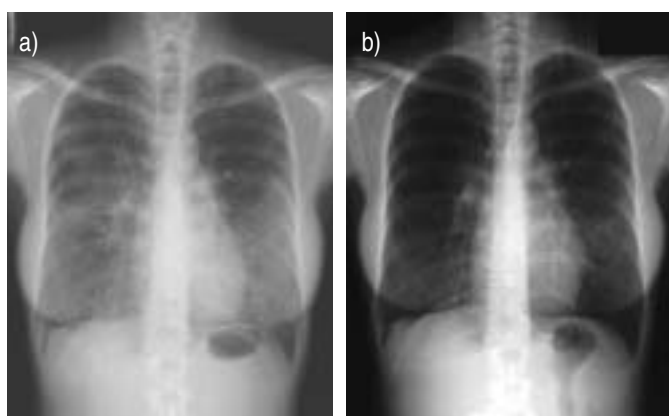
Chest radiographs at a) baseline and b) following 12 cycles of aerosolised granulocyte-macrophage colony-stimulating factor (24 weeks) in an index pulmonary alveolar proteinosis case.
